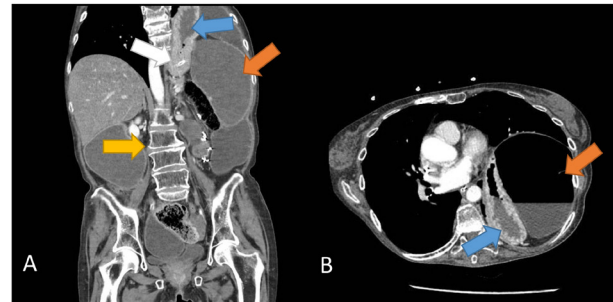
Computed tomography. A: Coronal plane. B: Transverse plane. Blue arrows: intrathoracic position of the stomach. Red arrows: dilated small bowel loops. White arrow: tip of the nasogastric tube. Yellow arrow: dented vertebra due to osteoporosis.
